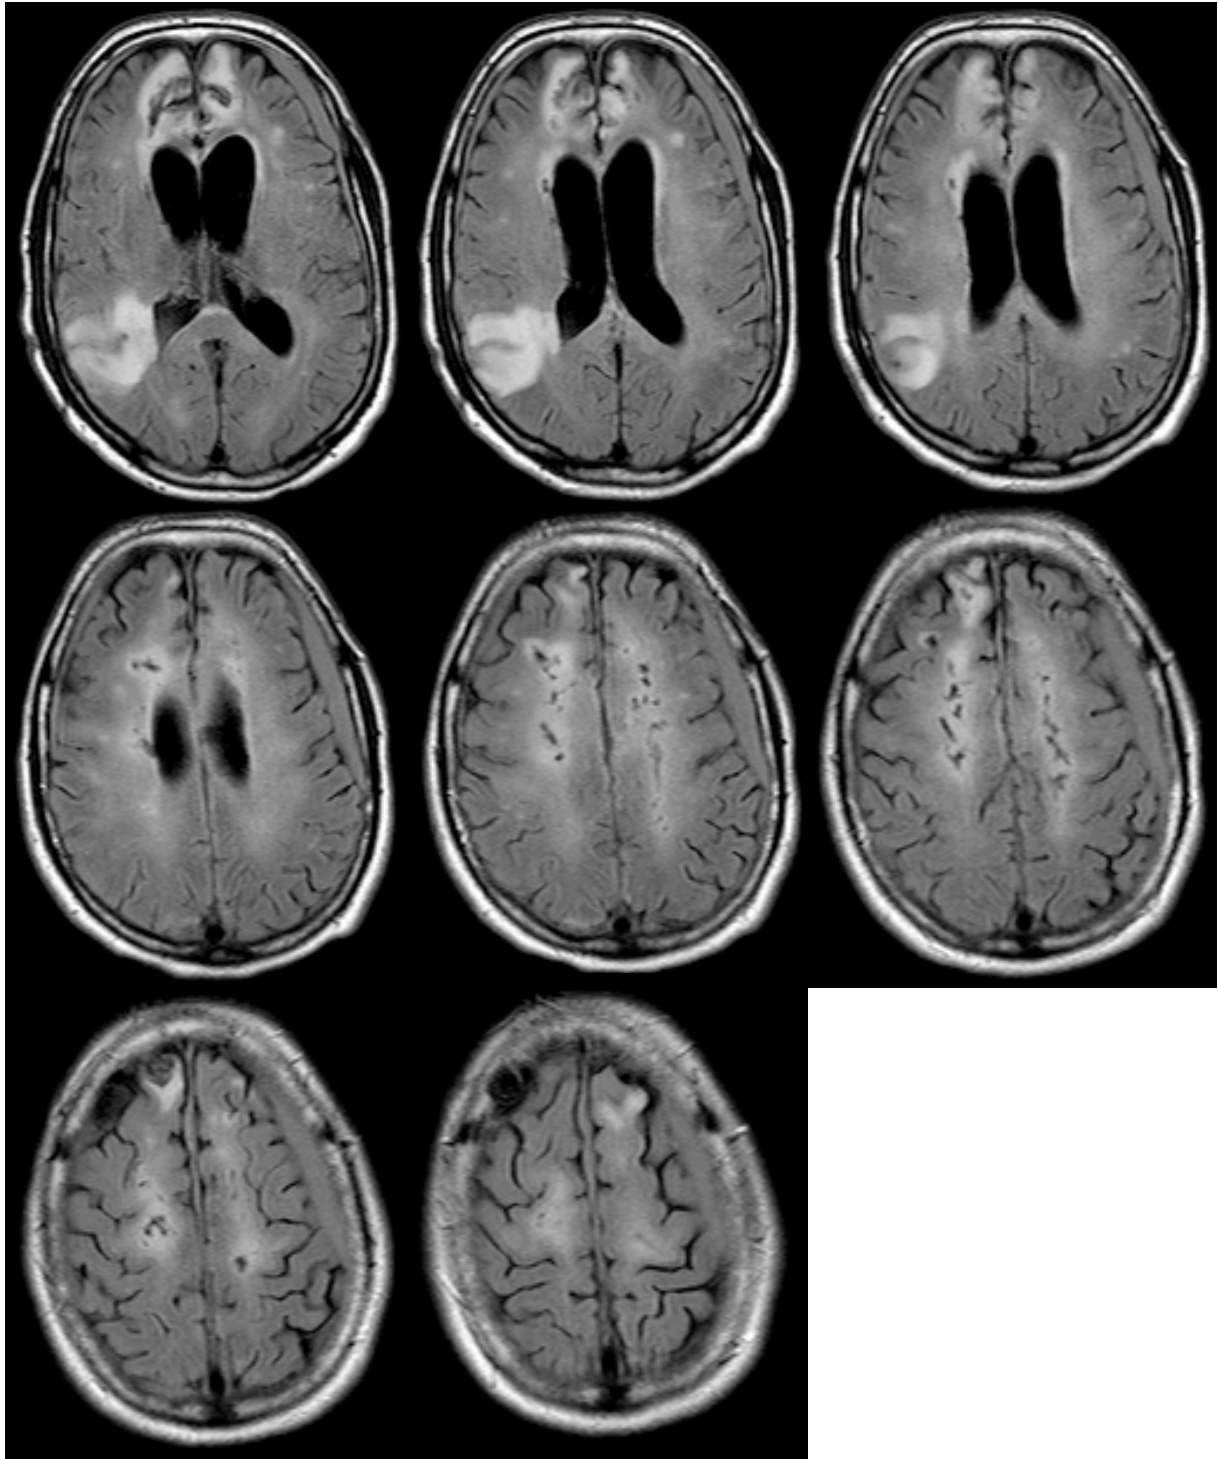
Example of 8 stackable MRI sections in the 8 DCE-CT sections in a FLAIR+ patient
